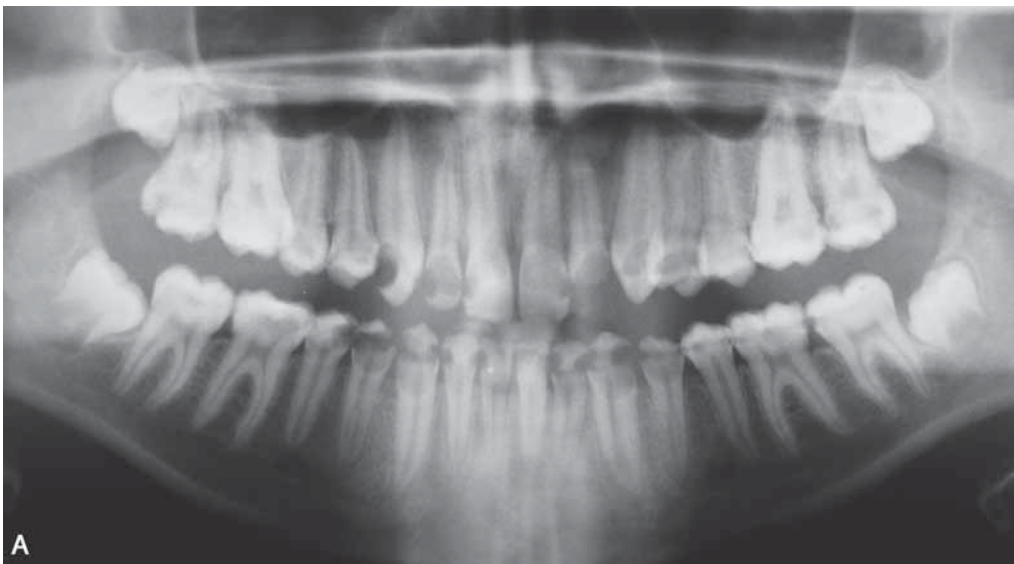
A. This is a Panorex (panoramic) radiograph of a 14-year-old girl showing rampant caries that progressed over many years resulting in a treatment recommendation to extract all teeth. This evidence of parental neglect was reason for the dentist to contact legal authorities for suspected child abuse/neglect. B. This is a photograph of this same 14-year-old girl showing rampant dental caries.
